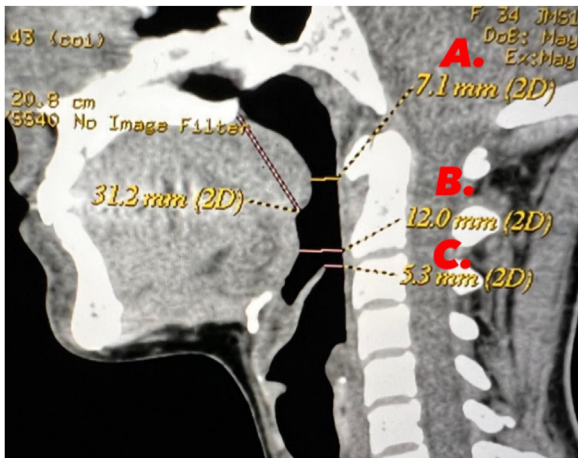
Example of computed tomography with lateral cephalometry. (A) Velum-pharynx space; (B) Posterior tongue base-pharynx space; (C) Epiglottis-pharynx space).
